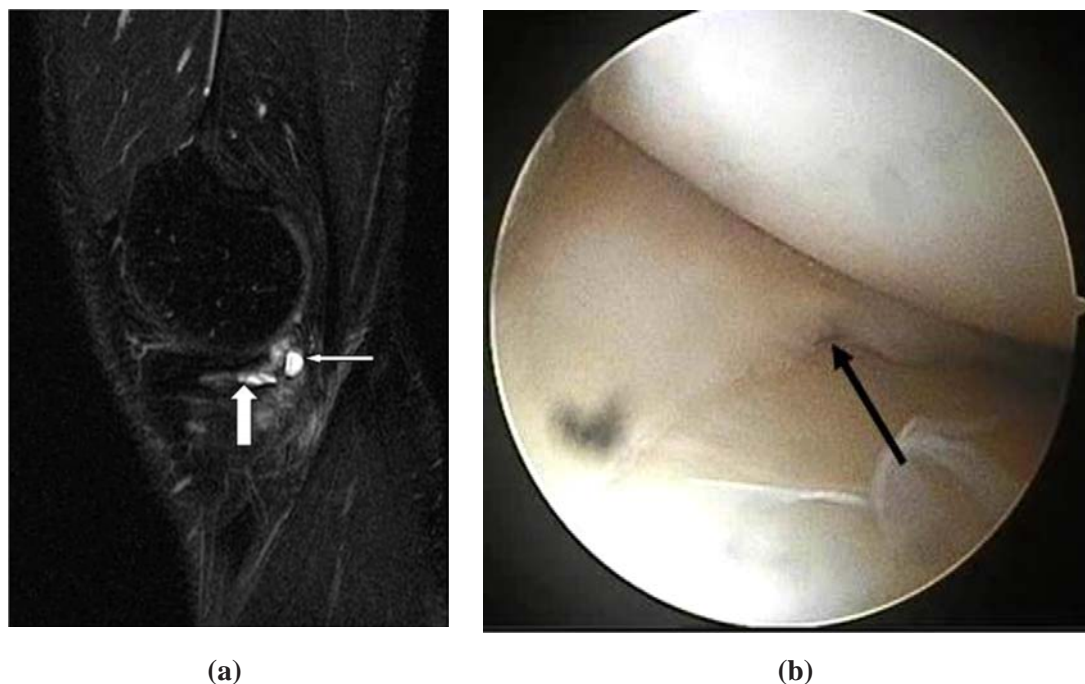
A 53-years-old man. (a) A high intrameniscal signal extending to the inferior surface at posterior horn of medial meniscus on sagittal T2-weighted image with fat suppression (thick white arrow). (b) Knee arthroscopy demonstrating a meniscal tear (indicated by a black arrow) at the same region. Parameniscal cysts adjacent to torn meniscus on sagittal T2-weighted image with fat suppression (thin white arrow) was seen in (a).
